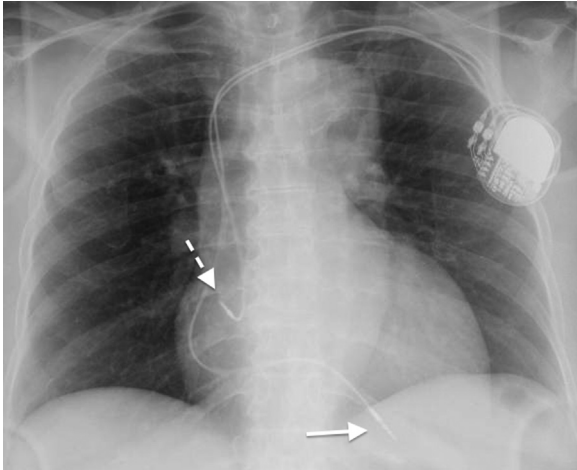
Supine frontal chest radiograph demonstrating a transvenous dual-chamber pacemaker with leads in the right atrium (dashed arrow) and right ventricle (solid arrow) and the generator in the classic left pectoral location.
